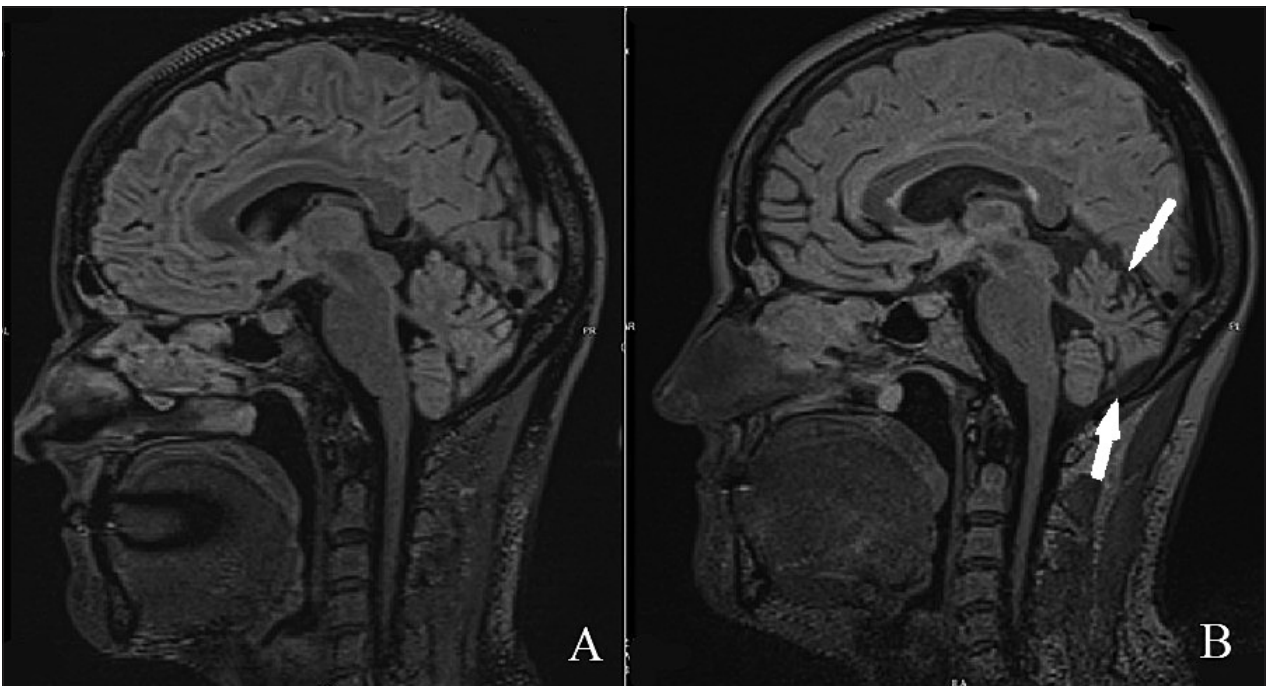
Comparison of 2019 (A) and 2022 (B) brain MRI in T2W/Flair mode (sagittal plane) (show atrophic changes).
